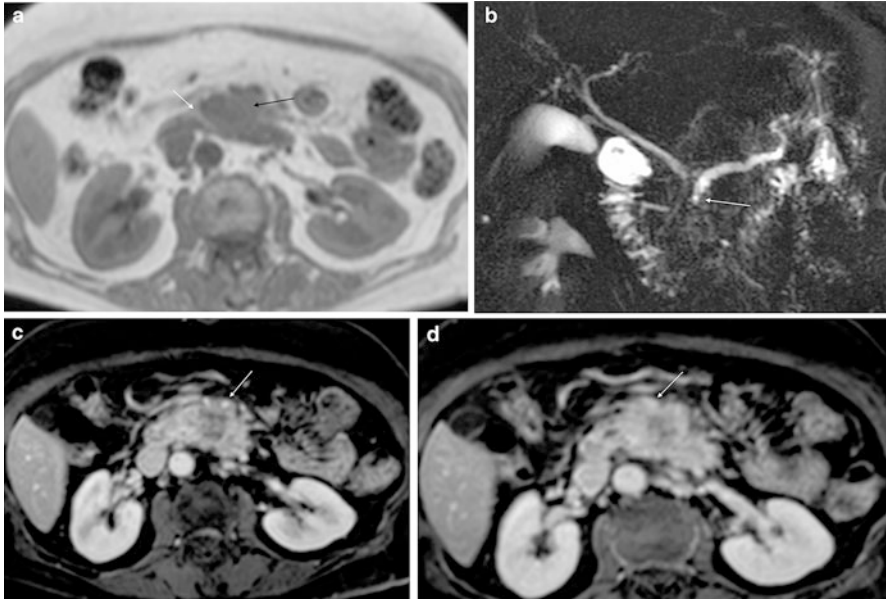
MR images demonstrating an uncinate process mass with vascular compromise. (a) Axial T1 in-phase scan demonstrating the low signal uncinate process mass (*black arrow*) with rim of normal high T1 signal pancreas (*white arrow*). (b) MRCP sequence demonstrating a dilated pancreatic duct with sharp cutoff at the uncinate process of pancreas (*white arrow*). (c) Axial T1 fat saturated post-contrast arterial phase scan demonstrating the hypoenhancing uncinate process tumor with encasement of the superior mesenteric artery. (d) Axial T1 fat saturated post-contrast portal venous phase scan demonstrating the hypoenhancing uncinate process tumor with involvement of the posterior wall of the superior mesenteric vein (*white arrow*)
